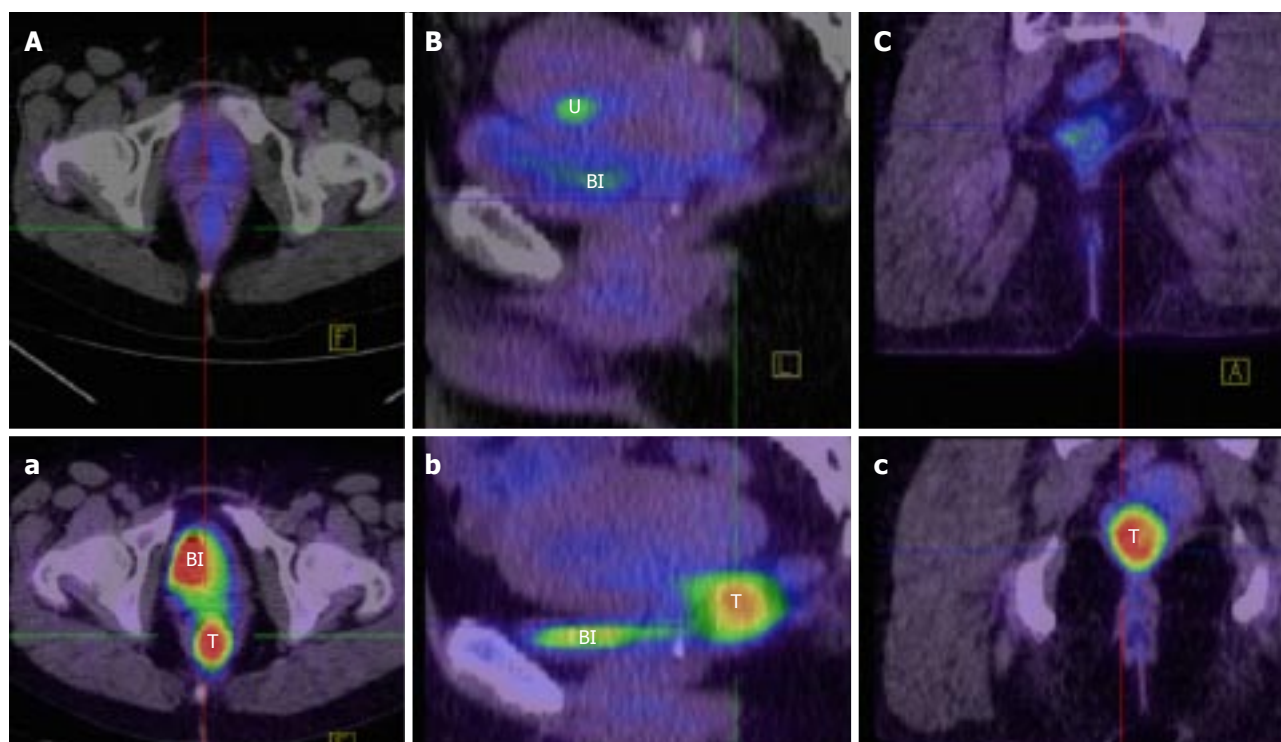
Positron emission tomography/computed tomography appearance of rectal squamous cell carcinoma. Pre (a, b, c) and post (A, B, C) treatment fused FDG-PET/CT imaging in axial (A, a), sagittal (B, b) and coronal (C, c) planes of a rectal SCC (T), demonstrating a complete metabolic response. [FDG is also visibly concentrated anteriorly in the bladder (BI) in images a, B, b, and in the endometrium (U) in image B (menstruation)]. FDG: Fluorodeoxyglucose; CT: Computed tomography; PET: Positron emission tomography; SCC: Squamous cell carcinoma.
